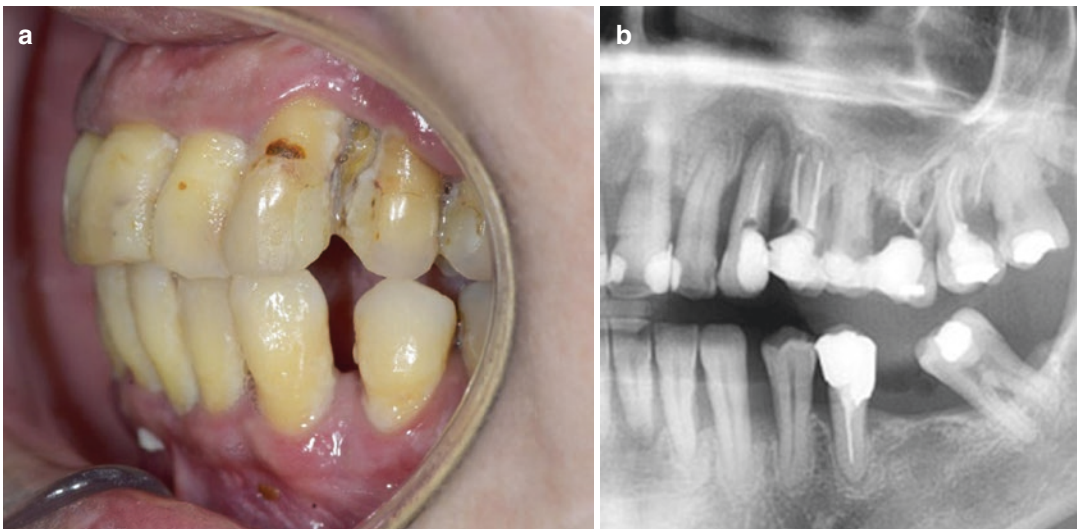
(a) Patient with diabetes mellitus demonstrating periodontal breakdown, periodontitis, and soft tissue necrosis. (b) Panoramic radiograph
